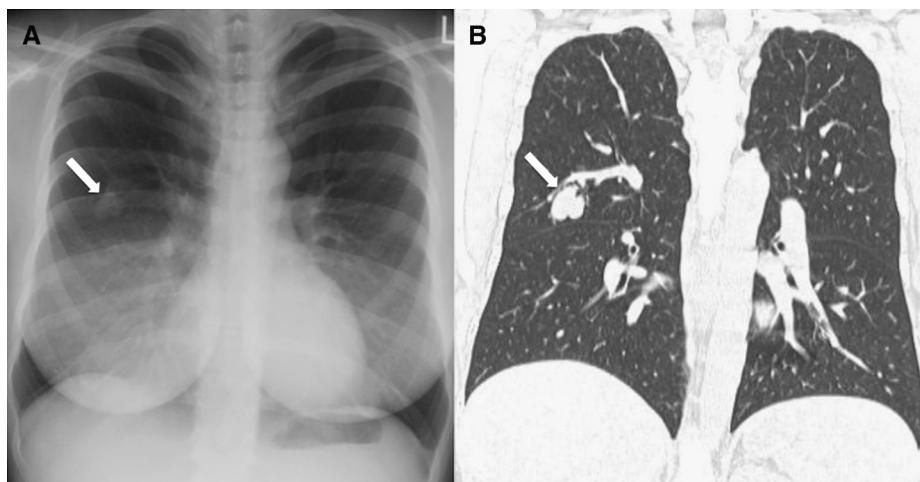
A 30-year-old woman with hereditary hemorrhagic telangiectasia. (A) Frontal chest radiograph and (B) coronal computed tomography image, demonstrating a right upper lobe pulmonary arteriovenous malformations (arrows).
